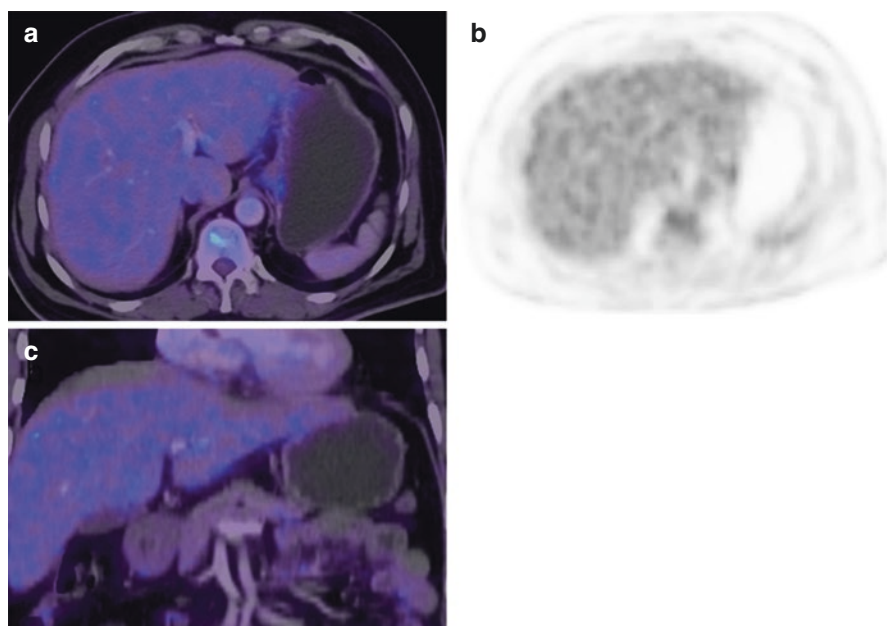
Physiological FDG uptake in the liver (a, c). Fine mottled appearance of physiological FDG uptake in the liver made out in PET image
